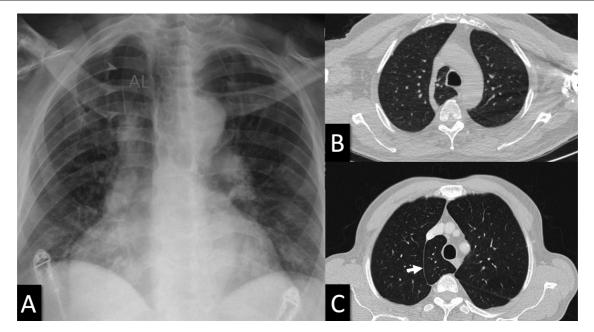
Chest frontal view radiograph (A) demonstrating the hyperdense lateral borders (arrowheads) of the azygos lobe (AL). Radiographs were taken with a 32kW Mobile X-ray unit (70 kVp, 320 mA, 0.5 sec). Superior (B) and inferior (C) axial CT images identifying the azygos vein (B) which separate the azygos lobe from the superior lobe. CT imaging was high resolution CT (HRCT) (slice thickness: 1 mm, scan time: 1 sec, 120 kV, 100 mA). The white arrow (C) shows the boundary of the lobe which is separated by 2 layers of visceral and pleura.
